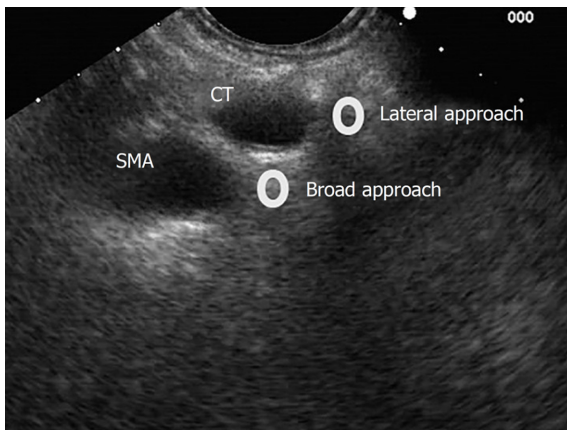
Lateral and broad approaches for endosonography-guided celiac plexus neurolysis. SMA: Superior mesenteric artery; CT: Celiac trunk.
